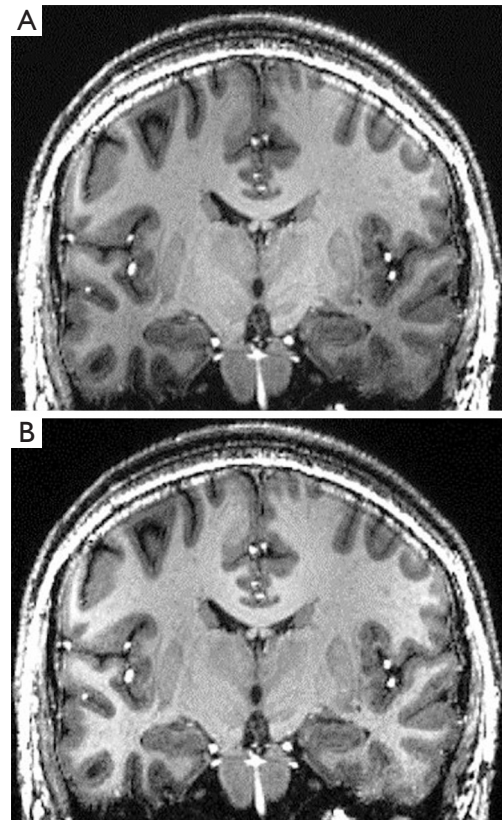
T1-weighted coronal MPRAGE images before (A) and after (B) signal inhomogeneity correction. Gradual signal decrease toward the skull base is corrected. MPRAGE, magnetization-prepared rapid gradient echo.
